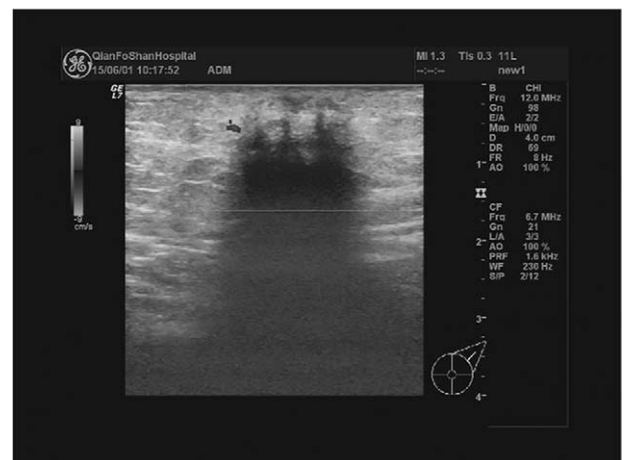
Ultrasound demonstrated a 18 mm×13mm mass, hypoechoic group in its center with blurred boundaries, a homogeneous internal echo, and a significantly attenuated rear echo.
